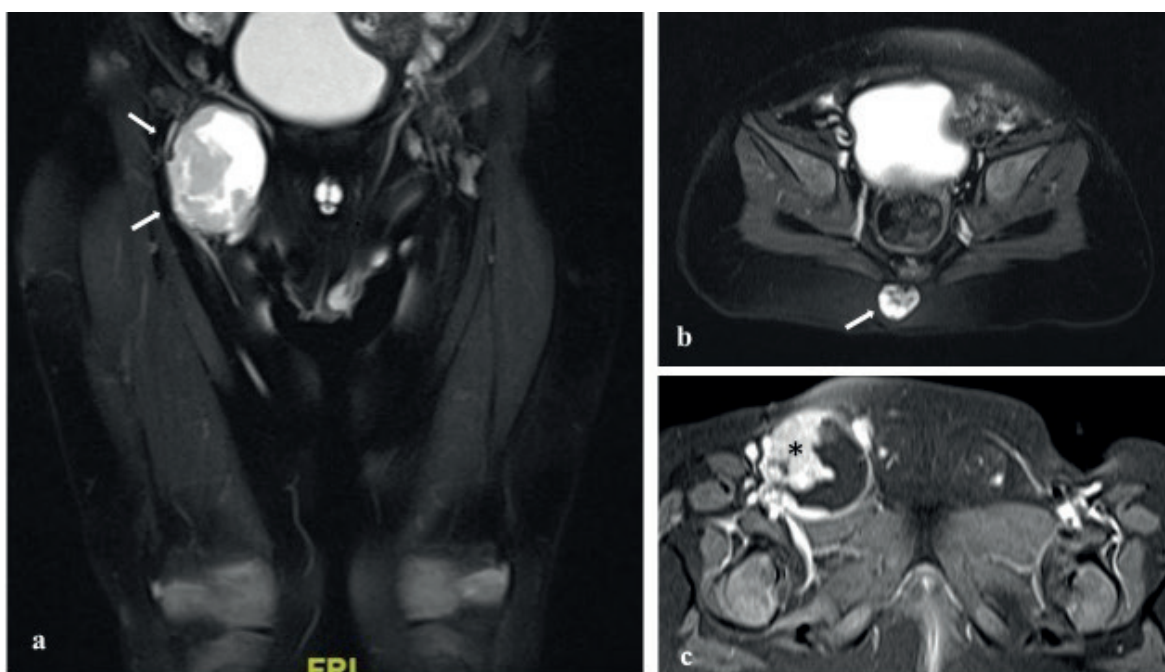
Coronal (a) and axial (b) fat saturated T2-weighted MR images show radiologically similar masses (arrows) containing solid and cystic areas in the right inguinal region (a) and in the coccygeal region (b). Axial fat saturated post-contrast T1-weighted MR image (c) shows contrast-enhanced solid component (*) of the inguinal mass.
